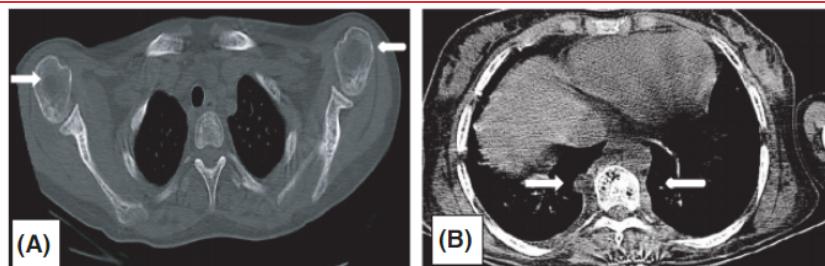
High-resolution computed tomography (HRCT) of the chest. (A) Bone window of chest CT showing exaggerated marrow trabeculae of both scapulae and ribs. Both humeral heads show lytic lesions suggestive of osteonecrosis. (B) Mediastinal window of CT chest showing paraspinal soft tissue mass bilaterally in the thoracic region, denoting extramedullary haemopoiesis.
